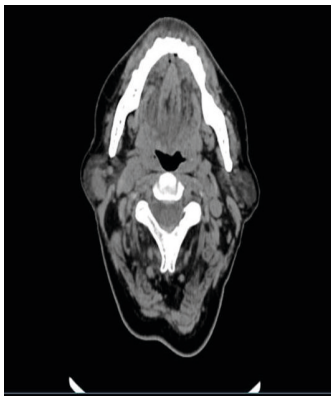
CT scan demonstrating injury in the right parotid.
